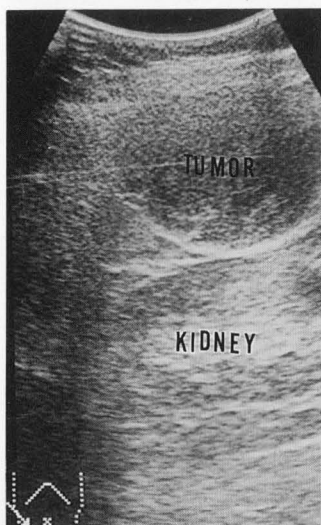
Abdominal ultrasonography. The tumor 6.3×4.9cm in size is seen between liver and right kidney developing from the thoracic wall. The echogram shows the tumor with smooth surface, uniform low echo and strong back echo.
